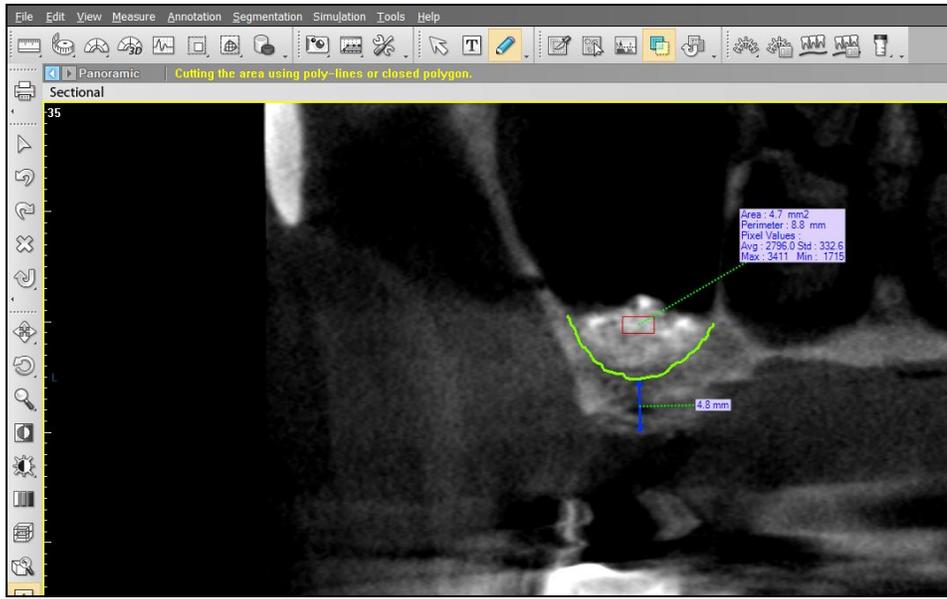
Cone-beam CT scan after 6 months from sinus augmentation reveals very high radiodensity values within the grafted site.
